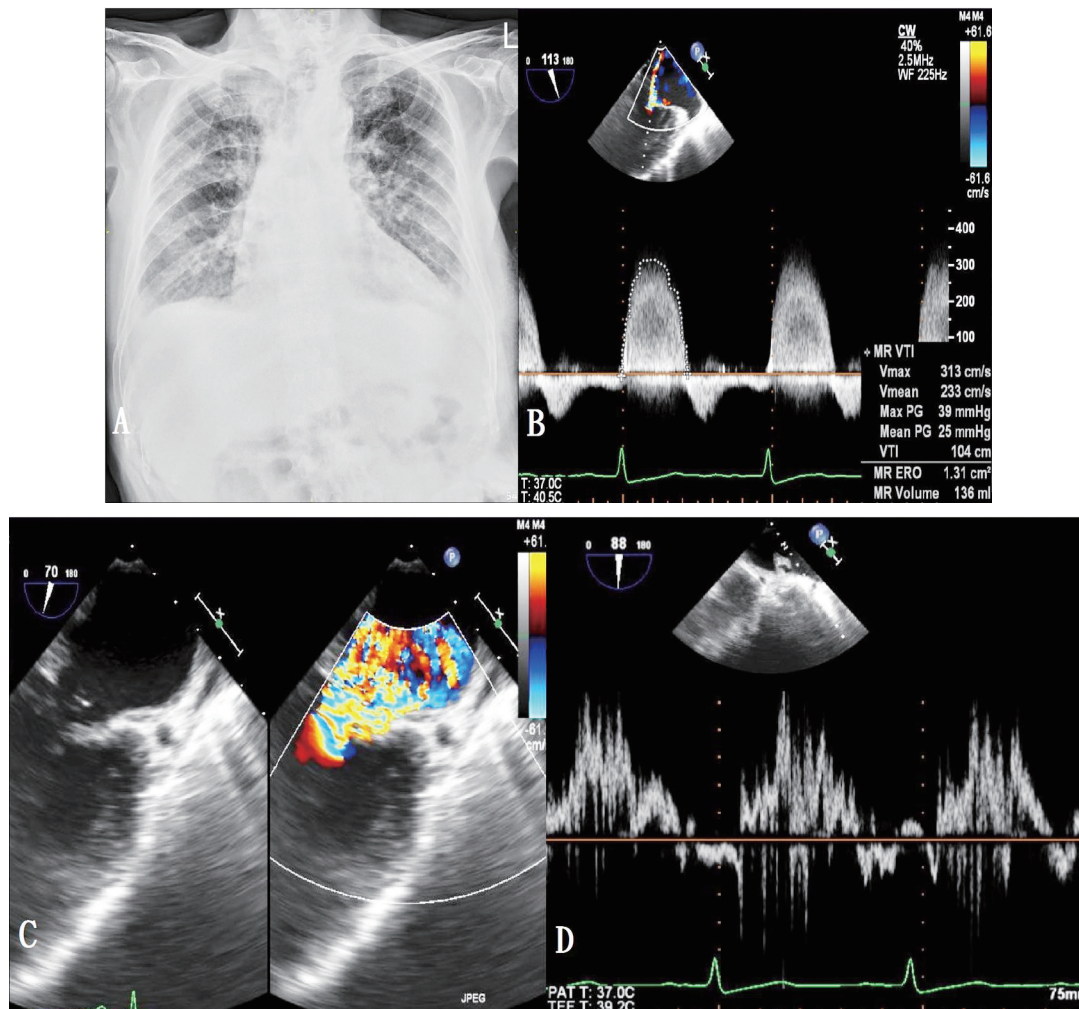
(A) Lung edema was observed at hospitalization. (B-D) Transesophageal echocardiography reveals severe mitral regurgitation with effective regurgitant orifice of 1.31 cm² and significant pulmonary vein flow reversal.
